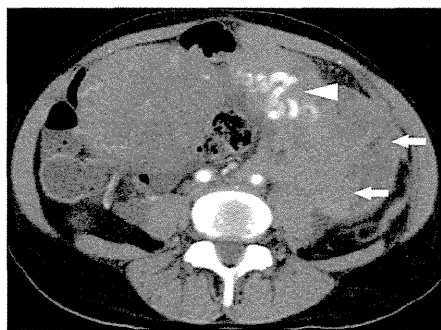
Abdominal computed tomography scan after injection of iodine contrast media on admission at 2 days after delivery. Transverse plane showed a large left retroperitoneal hematoma (arrows). Tortuous vascular structures on the left side of uterus (arrow head) suggested vascular aneurysm. No extravasation was found in this image.
